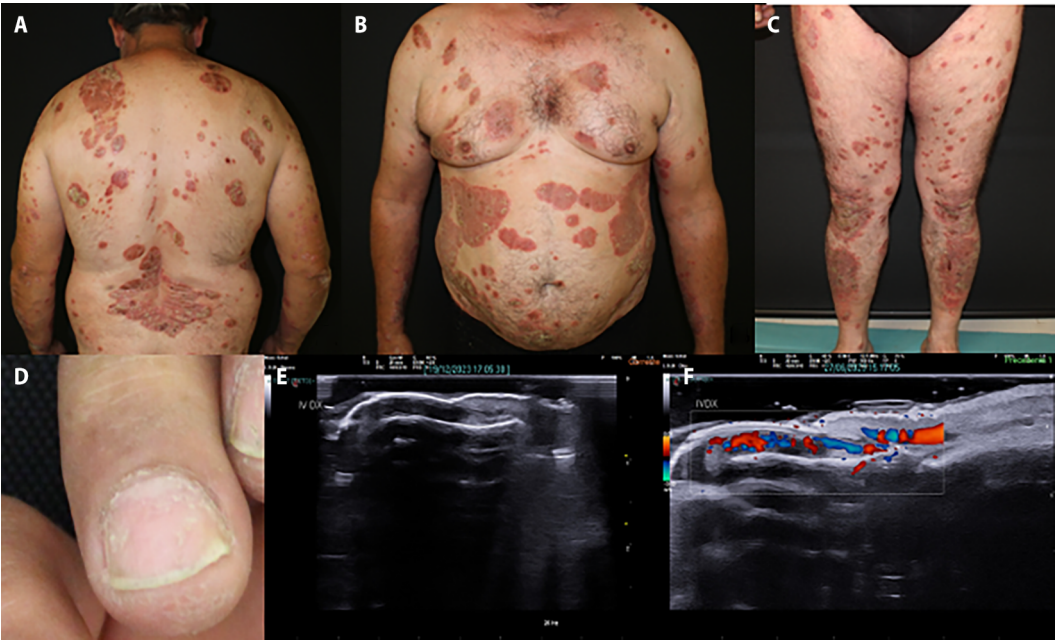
(A-C) A clinical case of a male patient, 54 years old, PASI 38.8, BSA 65, BMI 28 (D) with a coexistent mild nail involvement characterized by pitting and onycholysis (fourth right finger NAPS 5), (E) BUNES morphometry score 3, and (F) BUNES power Doppler 6.
